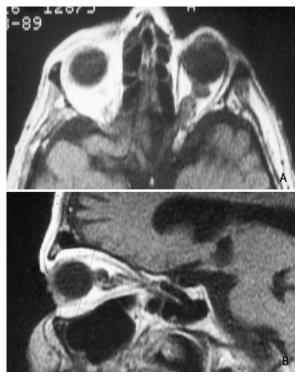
(A) Axial and (B) sagittal T1-weighted MRI images show tubular thickening of the left optic nerve showing elongation and kinking at midorbit secondary to optic nerve glioma. The patient did not have neurofibromatosis.
